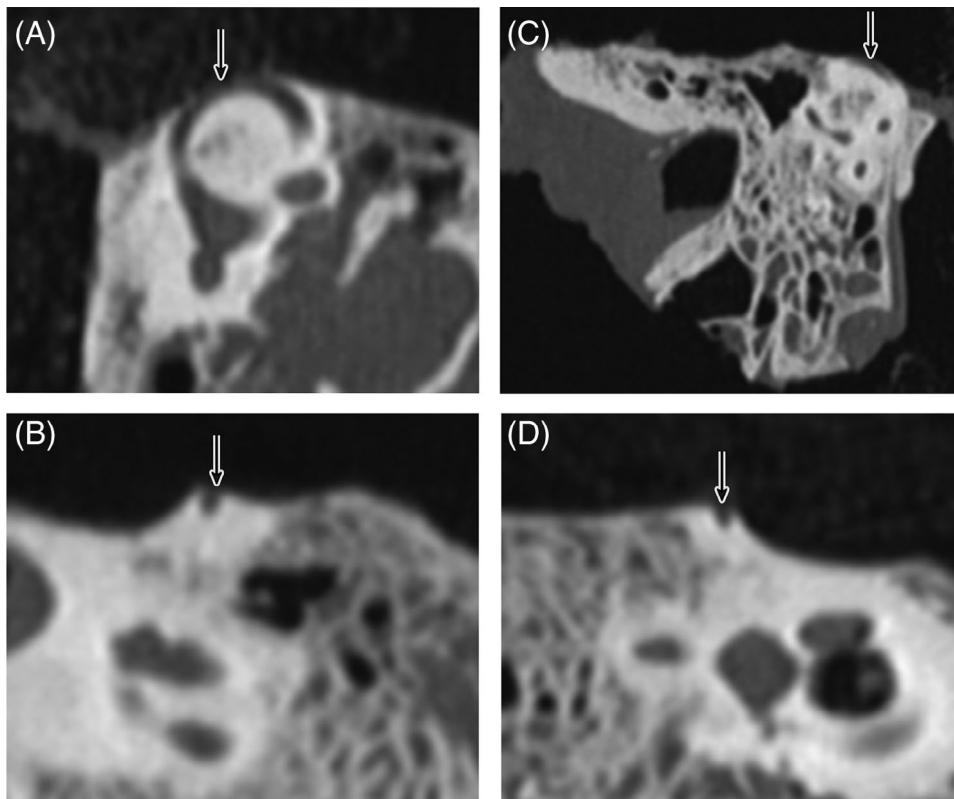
Computed tomography scans of the temporal bone: A, Pöschl view of the right ear; B, Stenver view of the right ear; C, Pöschl view of the left ear; and D, Stenver view of the left ear. These scans demonstrate canal dehiscence of the right superior semicircular canal (arrow), and dehiscence of the left semicircular canal. On the left, the bony partition between the superior semicircular canal and the middle fossa dura appears to be thinned but intact (C)
